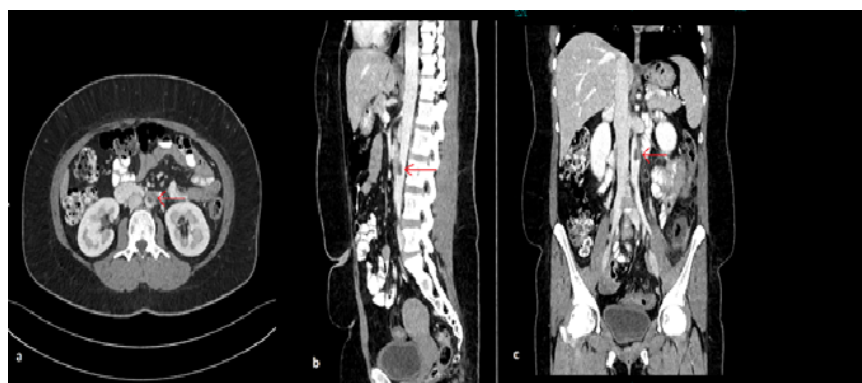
(a) Axial CT. (b) Sagittal CT. (c) Coronal CT abdomen with contrast showing a filling defect in the abdominal aorta at the level of L3 vertebrae consistent with aortic thrombus (arrow).
